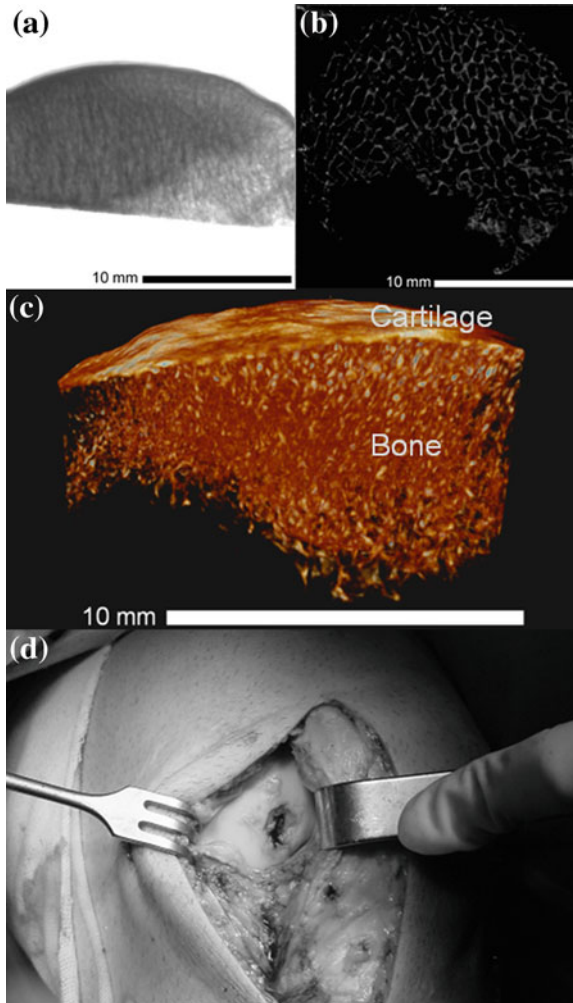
a An X-ray image of a freeze-dried human OC tissue (OA knee) acquired with a high-resolution micro-computed tomography equipment, Skyscan 1072 scanner, (SkyScan, Kontich, Belgium). b 2D and c 3D reconstructions of the images using CT Analyser and CTvox, image-processing softwares from SkyScan. d An OC lesion in the human knee
